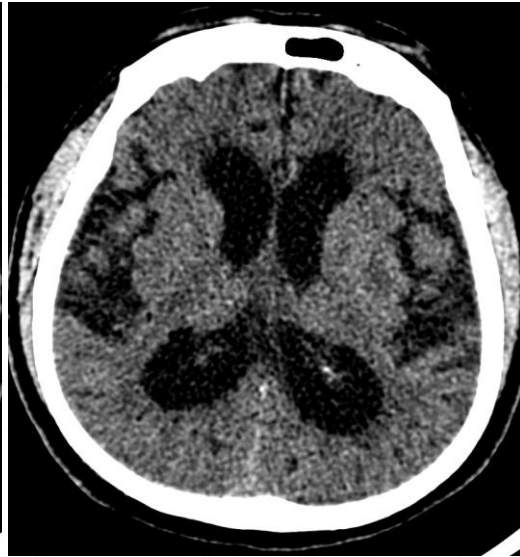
Post MT showing no evidence of increase in Infarct size (ASPECTS 7)/HI transformation
